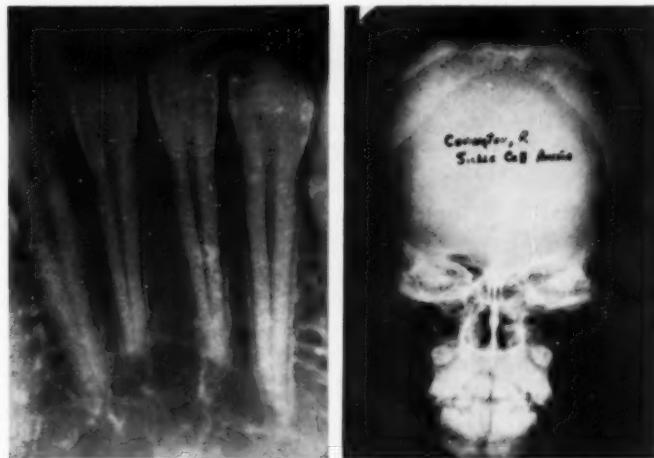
X-ray of alveolar process and teeth of mandible showing increased radiolucency and "step-ladder" appearance of trabeculations.
